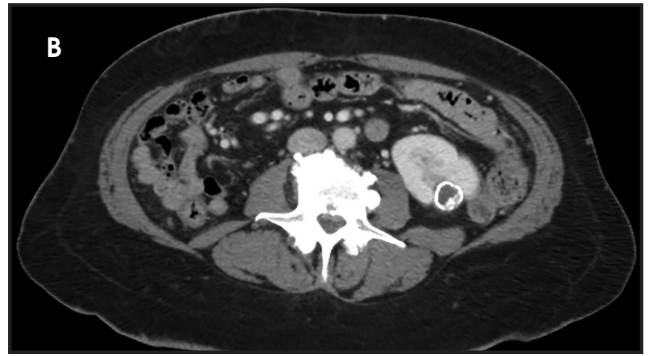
(A) Bosniak category II cyst. Sagittal contrast-enhanced CT image shows a lobulated renal cystic mass with few thin septations that demonstrate fine calcifications. (B) Bosniak category IIF cyst. Axial contrast-enhanced CT image shows a left renal cyst with dense calcifications without any enhancing septations or solid components. (C) Bosniak category III cyst. Axial contrast-enhanced MR image shows a well-defined cystic lesion in the left kidney with multiple enhancing septations. (D) Bosniak category IV cyst. Coronal contrast-enhanced CT image shows a well-defined cystic lesion in the left kidney that enhancing solid components and septations. This was proven to be extensively cystic, clear cell renal cell carcinoma on pathologic examination.
